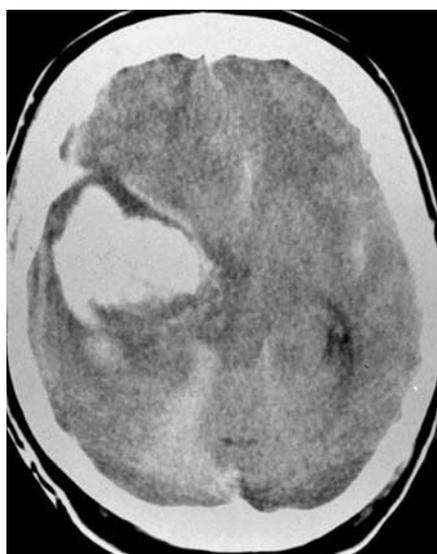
Right temporal lobe intracerebral hemorrhage due to a ruptured MCA aneurysm. Beside basal subarachnoid hemorrhage CT reveals brain edema, compression of the basal cisterns and the cerebral peduncle
